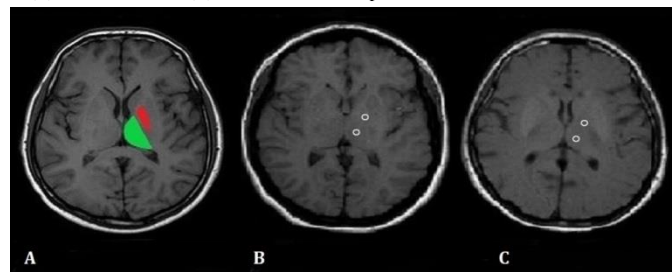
Axial unenhanced T1-weighted images demonstrating the anatomical locations of globus pallidus in red, and thalamus in green (A), and the exact locations of the region of interest (ROI) where the measurements were performed at left globus pallidus and left thalamus in the first (B) and the last MRI (C) examinations of the patient
